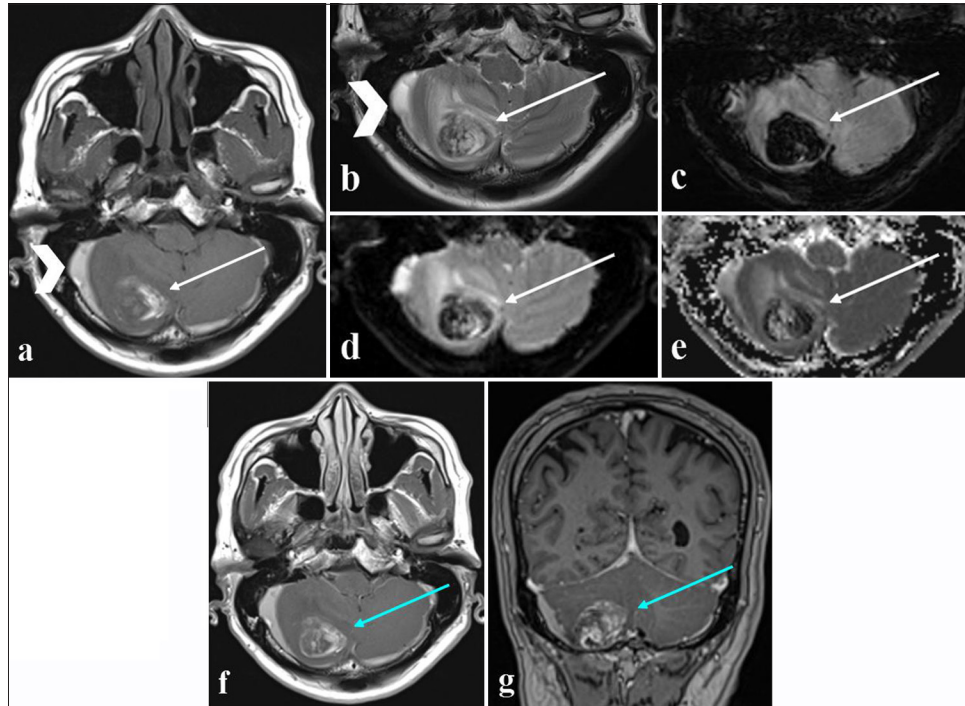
Multi-modality magnetic resonance imaging of a 67-year-old man with severe headache. (a) Axial T1-weighted image showing lesion with eccentric hyperintense signal in the right cerebellar lesion (white arrow) with hyperintense signal along the bilateral cerebellar convexities (white arrowhead) from bilateral subdural hemorrhages in the posterior fossa. (b) T2-weighted imaging showing hyperintense right cerebellar lesion (white arrow) with similar hyperintense signal along the bilateral cerebellar convexities (white arrowhead). (c) Susceptibility-weighted images showing marked susceptibility artifact in the right cerebellar hemisphere (white arrow). The lesion contains a large amount of hemosiderin and is consistent with a hemorrhagic lesion. (d) Axial diffusion-weighted imaging with hyperintense foci within the right cerebellar lesion (white arrow) and (e) Apparent diffusion coefficient images with corresponding hypointense foci within the right cerebellar lesion (white arrow), in keeping with restricted diffusion within the medial aspect of the lesion. It indicates an area of high cellularity within the lesion. (f) Axial T1-weighted post-contrast images demonstrate the lesion having an eccentric peripheral enhancement and areas of hypoenhancement within its center (light blue arrow), also seen on (g) coronal T1-weighted post-contrast images (light blue arrow); the latter is due to the presence of hemosiderin substance. The pattern of enhancement resembles a “bull eye” or “target” in appearance.
